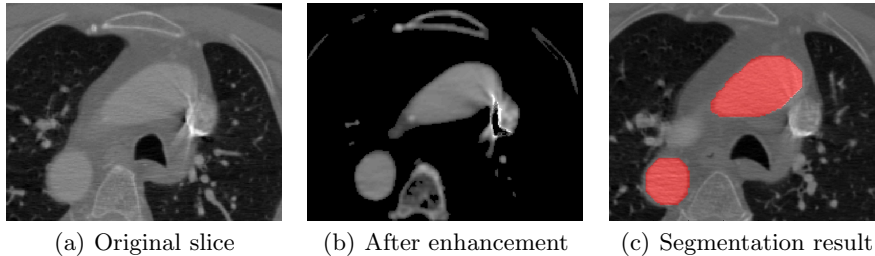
Automatic aorta segmentation: (a) CTA scan axial slice after downsampling and smoothing; (b) enhanced image; (c) aortic arch segmentation
